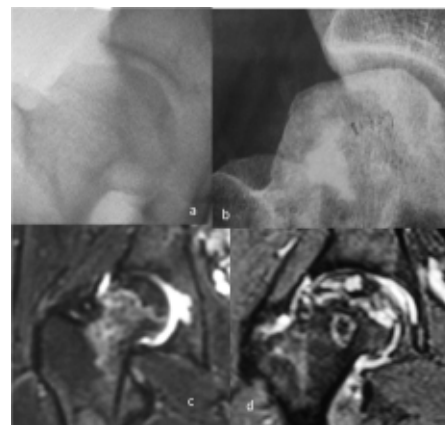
Comparison between preoperative (A) and 3 months post surgery Radiographs (b) with no progress in the lesion. The opacity due to calcium hydroxapatite can still be seen. C-preoperative MRI showing avascularity. d- 6 months postoperative MRI showing revascularisation
